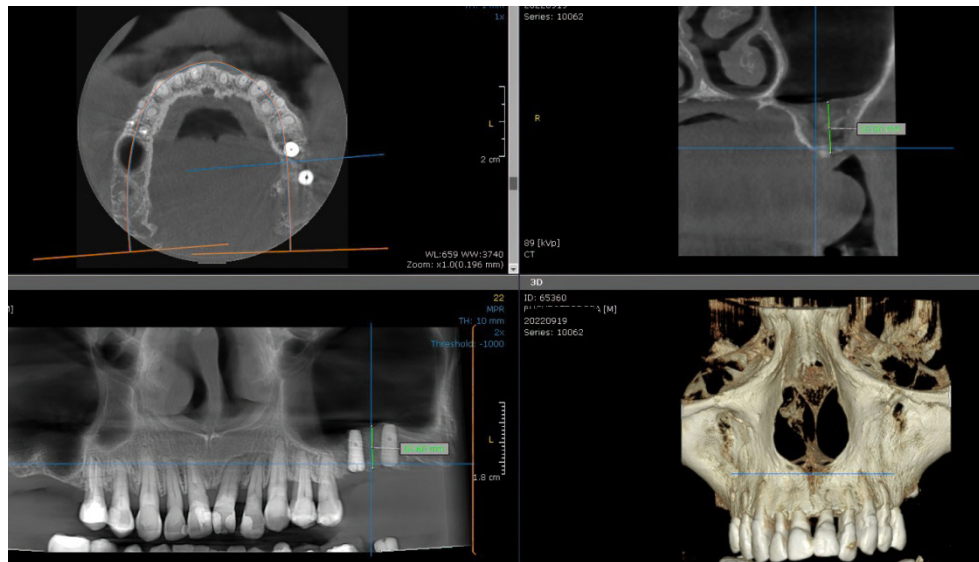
Postoperative CBCT measurement of the median distance that corresponds to the highest top of the sinus grafted (dome) or the apical point of the implant for the L-PRF sinus with simultaneous implant placement. The CBCT software provides multiple types of sections, cross-sectional, axial, panoramic.
